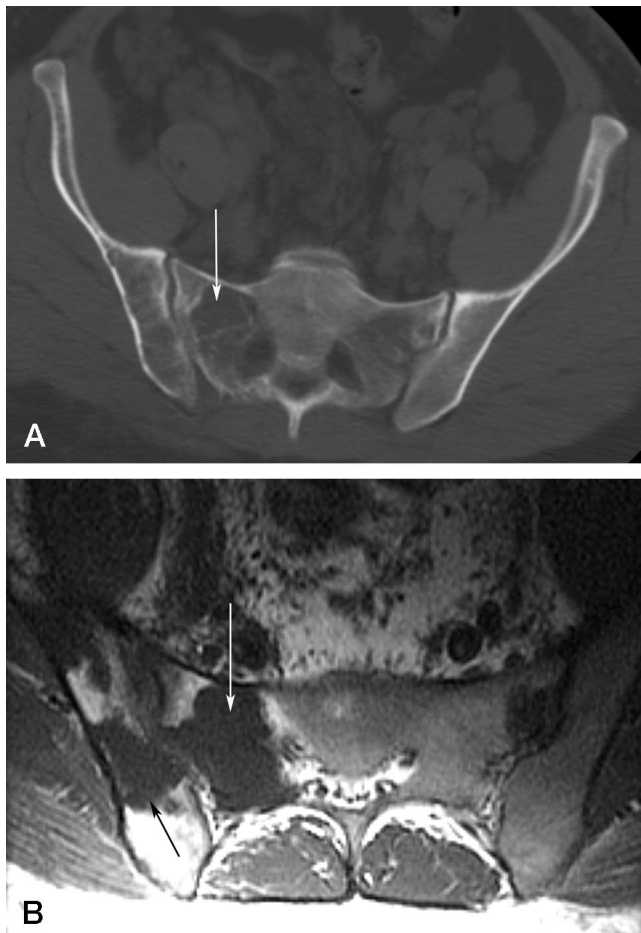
Computed tomographic (A) and (B) magnetic resonance imaging of the patient's sacrum prior to intervention demonstrate predominant lytic lesions within the sacrum (white arrows) and right ilium (black arrow).
